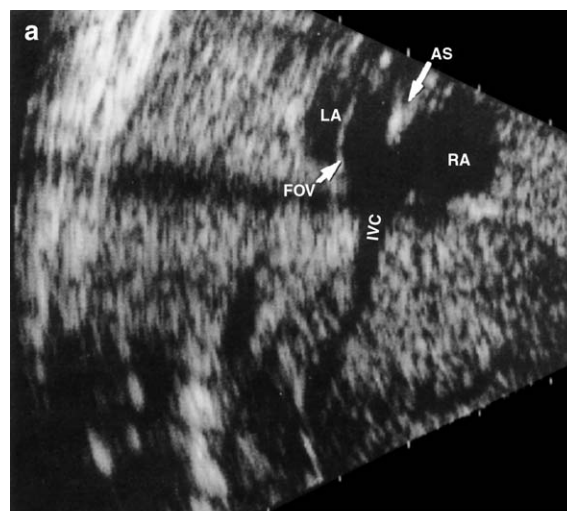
The foramen ovale acts as a flow distributor of the inferior venous inlet. (a) Ultrasound scan shows the inferior vena cava (IVC) and left and right atria (LA, RA). The atrial septum (AS) with its crista dividens (postnatal: limbus) faces the inlet of the IVC to divide the ascending column of blood. The terminal portion of the IVC expands, more to the left side, to receive blood from the liver and ductus venosus (DV). The high velocity, its position to the left and steep direction (b) makes the DV blood preferentially press open the foramen ovale valve (FOV) to enter the LA. IVC blood directed more anteriorly arrives predominantly in the RA. Increased pressure in LA or a premature apposition of FOV to the AS would divert more blood to the right. Reproduced with permission from ref.³⁶
